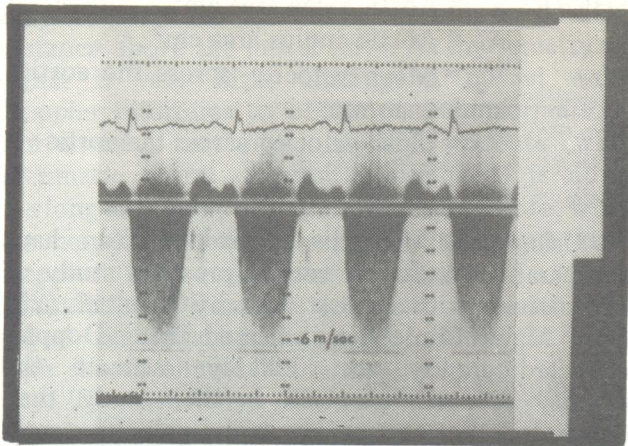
Continuous wave Doppler tracing in patient with mitral regurgitation (Apical view).
